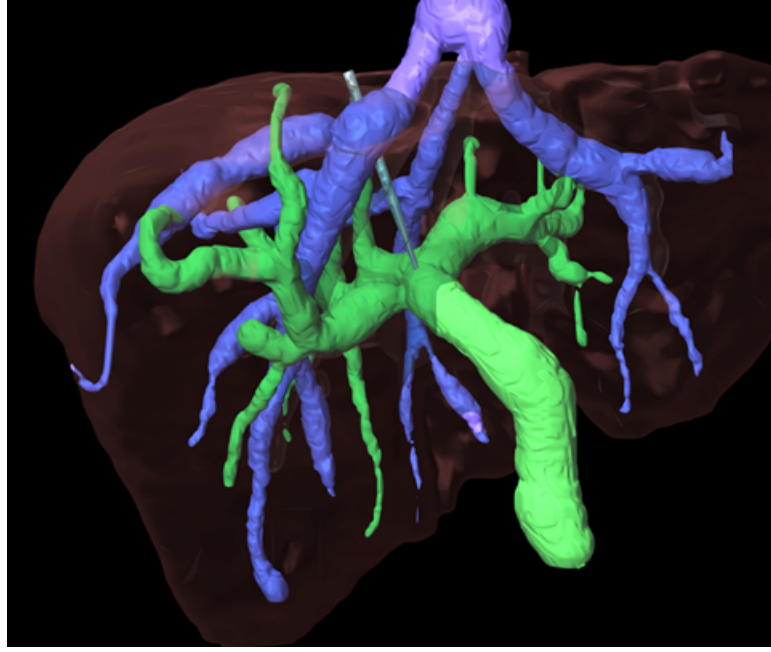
Three-dimensional model of the blood vessels in a patient’s liver, extracted from CT. A synthetic needle has been added to show the usual path of the TIPS needle from hepatic to portal veins. The image was rendered using 3D Studio Max<sup>TM</sup> and is viewed from the front of the patient.
